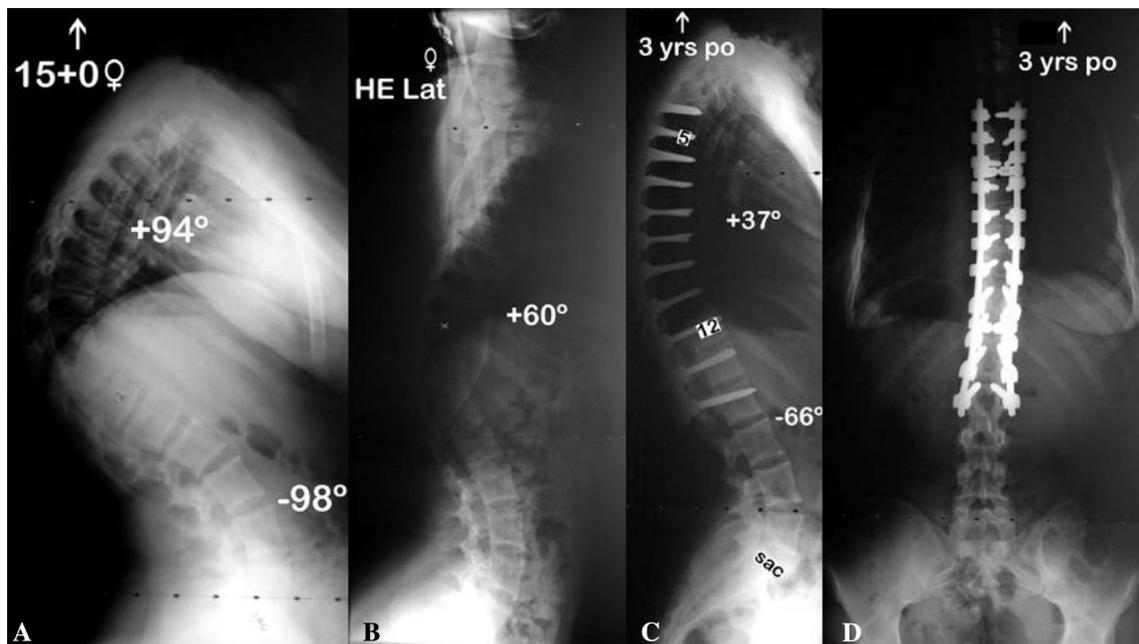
15-year-old male with Scheuermann's kyphosis. Preoperative upright lateral (a) and supine hyperextension, (b) X-rays showing reduction of curve from 94° to 60° . Postoperative lateral (c) and AP
